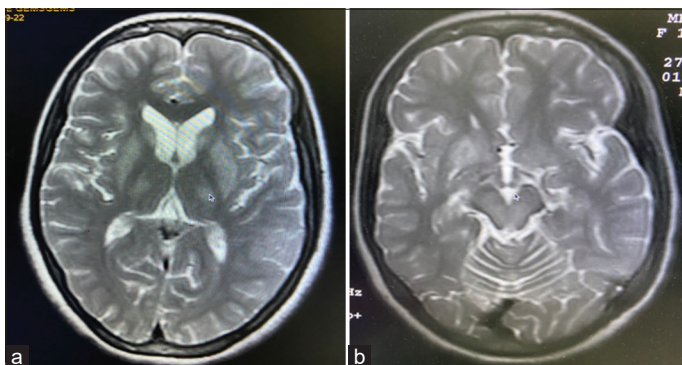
Magnetic resonance imaging showing (a) Hyperintensity in basal ganglia and thalami; (b) Hyperintensity in Midbrain
